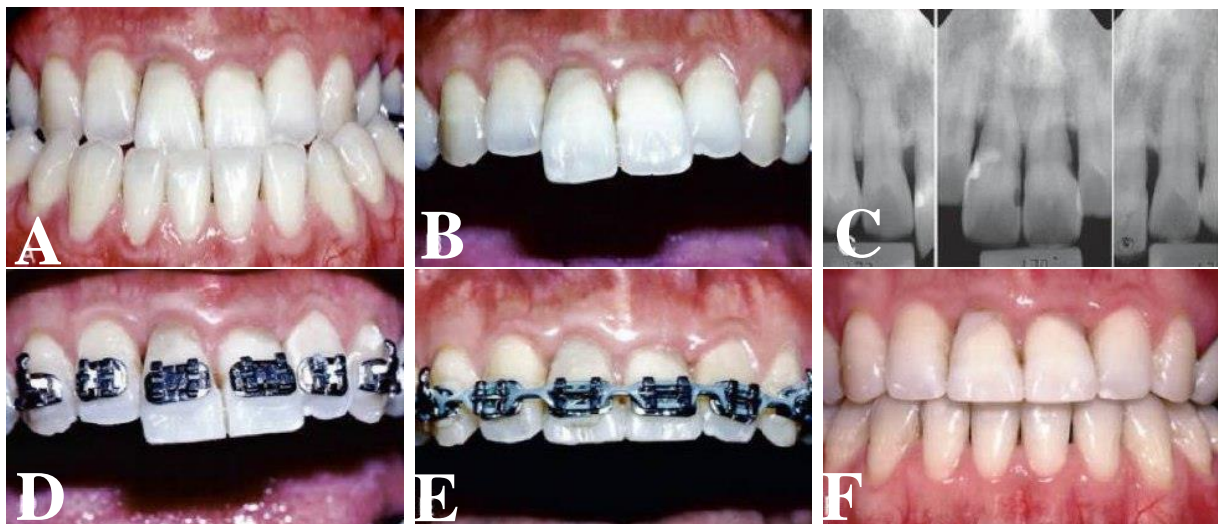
(Newman *et al.*, 2019). Before orthodontic treatment, (A): this patient had a significant class III malocclusion. (B): The maxillary central incisors had overerupted relative to the occlusal plane. (C): Pretreatment periapical radiography showed that significant horizontal bone loss had occurred. (D): To avoid creating a vertical periodontal defect by intruding the central incisors, the brackets were placed to maintain bone height. (E): The incisal edges of the centrals were equilibrated and (F): the orthodontic treatment was completed without intruding the incisors.
